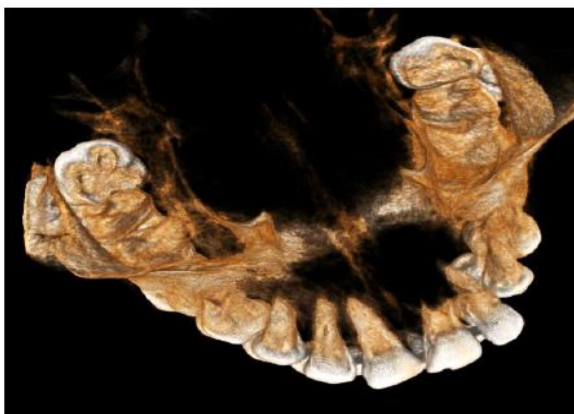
CBCT, transparent bone view, palatal region.
